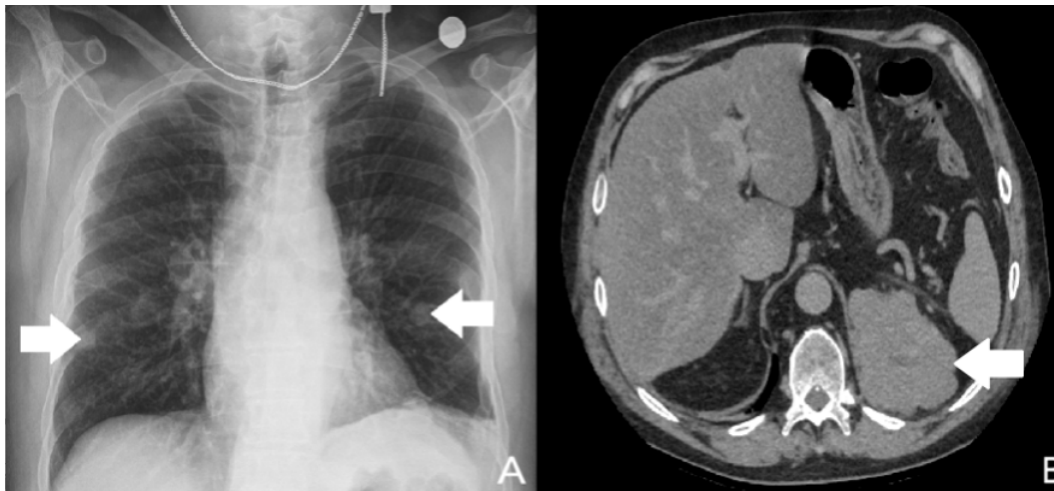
Chest X-ray demonstrating multiple coin-like nodules in both lungs, suggestive of metastatic lesions (white arrows, panel A). Axial CT scan of the abdomen with intravenous contrast displaying a heterogeneous lesion measuring 97×46 mm in the left suprarenal lesion (white arrow, panel B).
